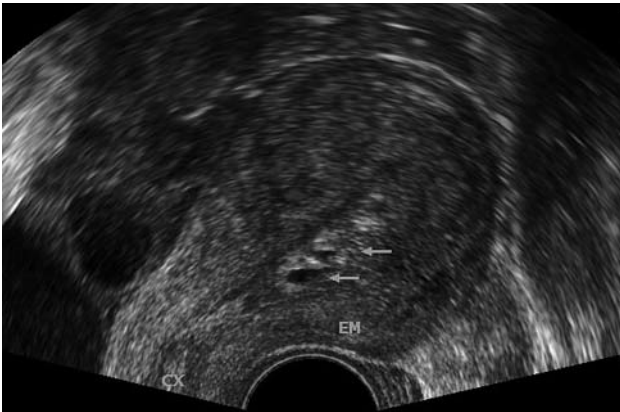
Transvaginal ultrasound showing retained gestational tissue (white arrow) in the endometrial cavity.
